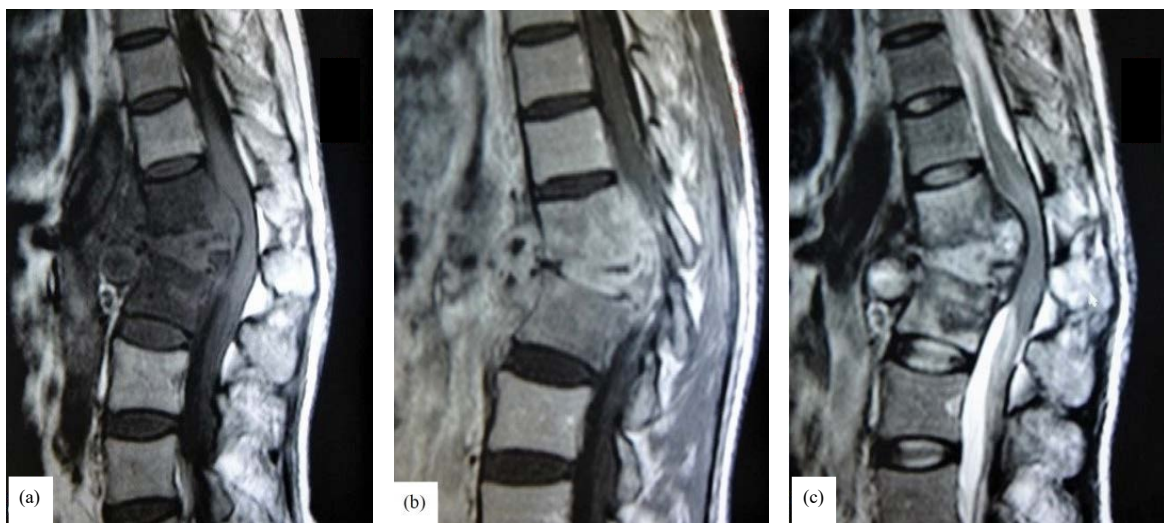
(a-c): Selected sagittal images of MRI of a patient with Pott's disease shows a destructive lesion in the region of the thoracolumbar junction of the spine with (a) Intermediate signal intensity (SI) of the content and altered SI of the vertebrae in T1WI, (b) Lesion shows marked peripheral enhancement in post-gadolinium T1WIs and (c) High SI of the content in T2WI
